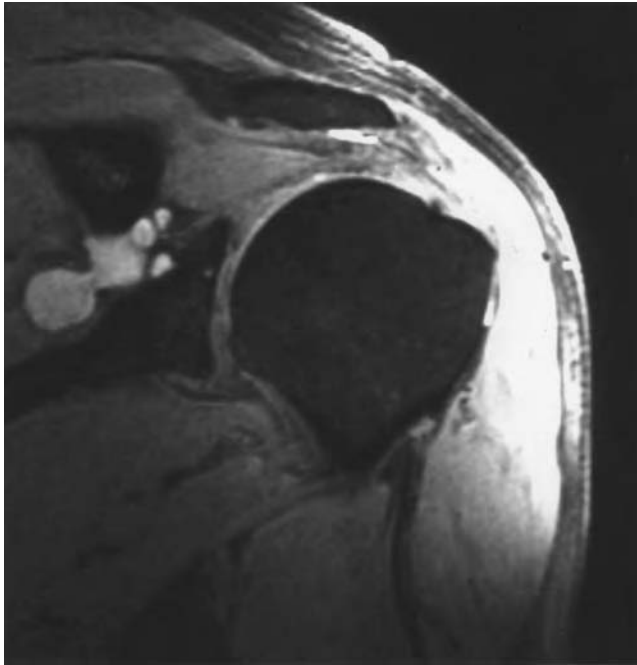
(top and below) MRI of suprascapular ganglion cyst.
